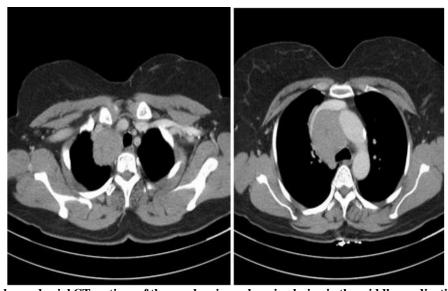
Contrast enhanced axial CT sections of thorax showing enhancing lesion in the middle mediastinum extending to superior mediastinum.
